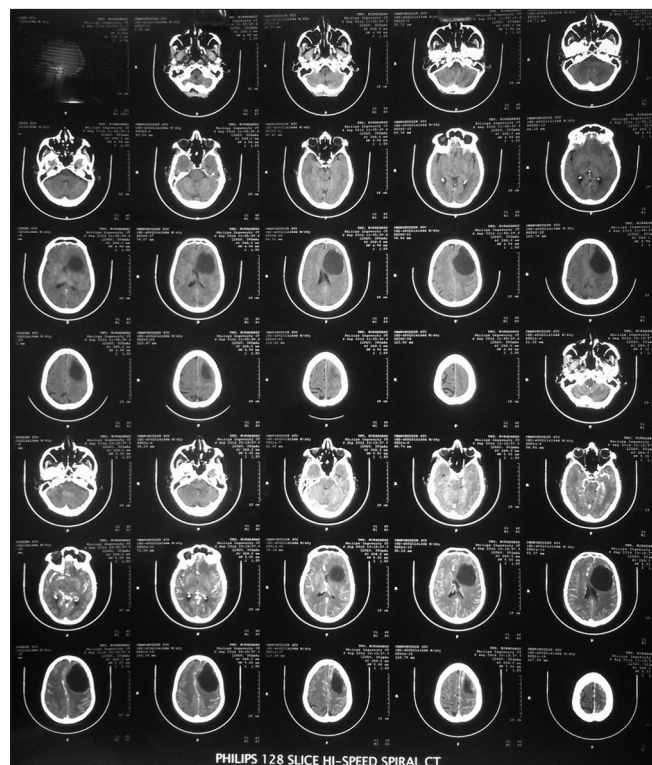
Magnetic resonance imaging brain showing a hypodense peripherally enhancing abscess approximately 73 mm × 56 mm with thick and heterogeneous outer wall and thin inner wall in the left fronto-parietal region
